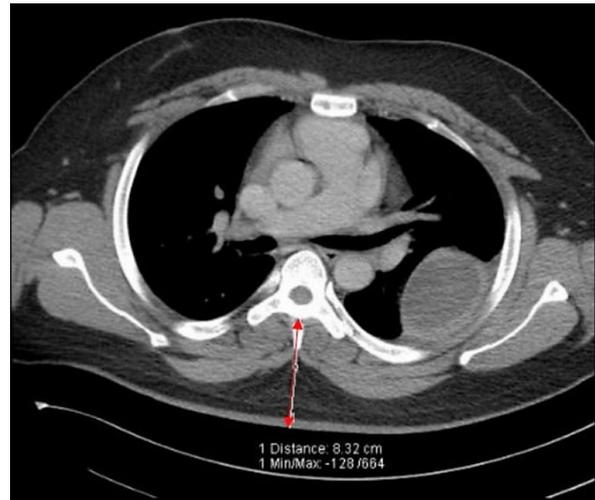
Transverse computed tomography of the mid-thoracic plane at level T5. Red arrow represents the perpendicular distance from skin to epidural space measuring at 8.32 cm.
